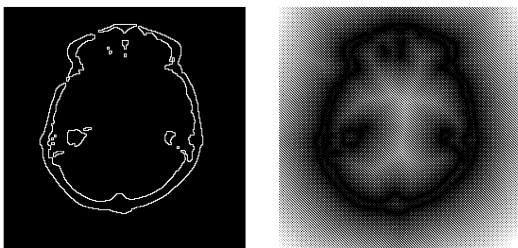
CT 2-D surface and its distance transformation image.
